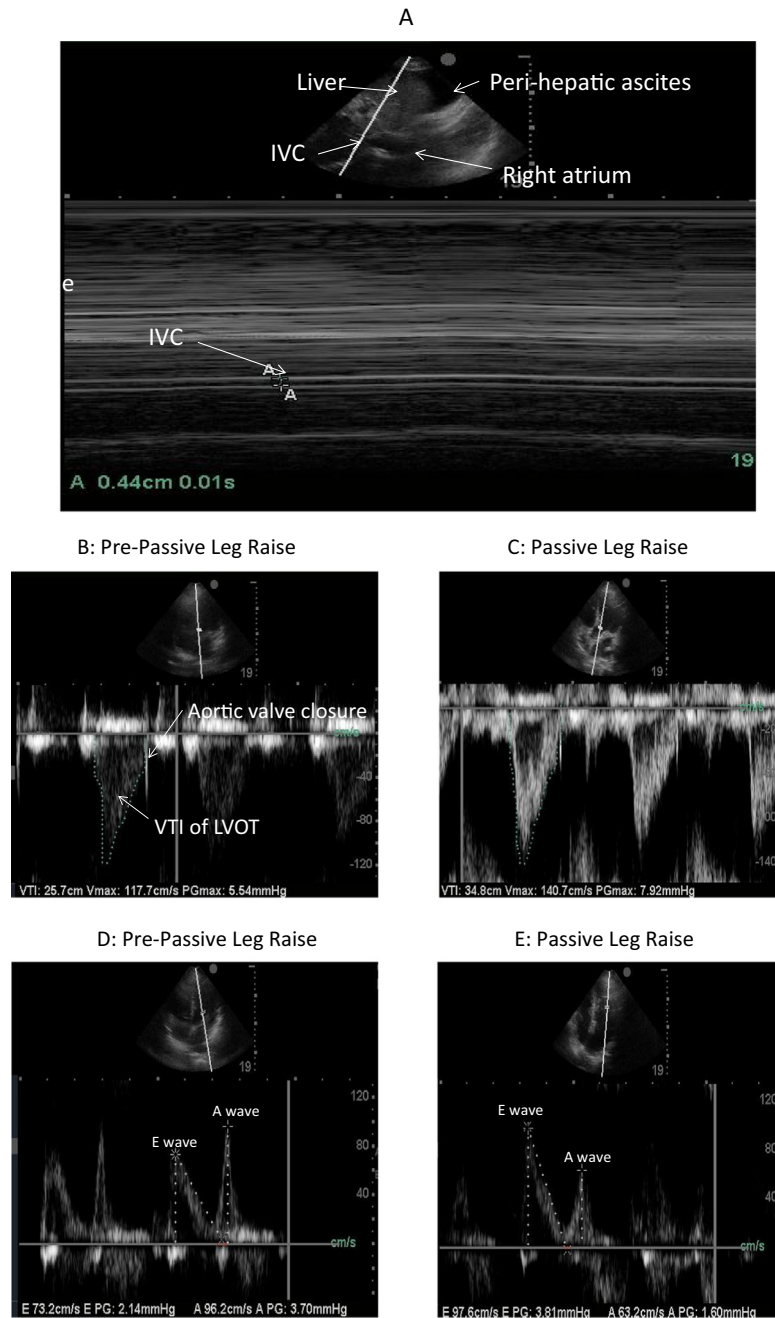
POCE evaluation of volume status preparacentesis. A, A 2-D and M-mode image of the IVC obtained from a subcostal view on a longitudinal axis is shown. The IVC measures 0.44 cm with minimal respiratory variation. This IVC size is indicative of a state of hypovolemia; however, the presence of significant intra-abdominal hypertension because of the presence of ascites may render a similar appearance. B and C, Pulse-wave Doppler images from an apical 5-chamber view of the left ventricular outflow tract (LVOT) showing a velocity time integral (VTI) increase from 25.7 cm (B) to 34.8 cm (C) following a passive leg-raise maneuver. This corresponds to a 35% increase in stroke volume. The area under the curve (designated by the white dots surrounding the Doppler wave (on the left side of each image) corresponds to the VTI of the LVOT and when multiplied by the cross surface area of the LVOT yields stroke volume in milliliters. To calculate stroke volume, the VTI (in cm) is multiplied by the cross surface area of the LVOT (in cm^2). D and E, Pulse-wave Doppler of mitral inflow from an apical 4-chamber view is shown. D, Pre-passive leg raise reveals an E velocity of 73.2 cm/second, with E/A reversal. E, The E velocity increased to 97.6 cm/second with normalization of the E/A pattern corresponding to a 33% increase in preload augmentation. This mitral inflow pattern with corresponding change with passive leg raise is consistent with hypovolemia. 2-D, 2-dimensional; IVC, inferior vena cava; POCE, point-of-care echocardiography; LVOT, left ventricular outflow tract; VTI, velocity time integral.
